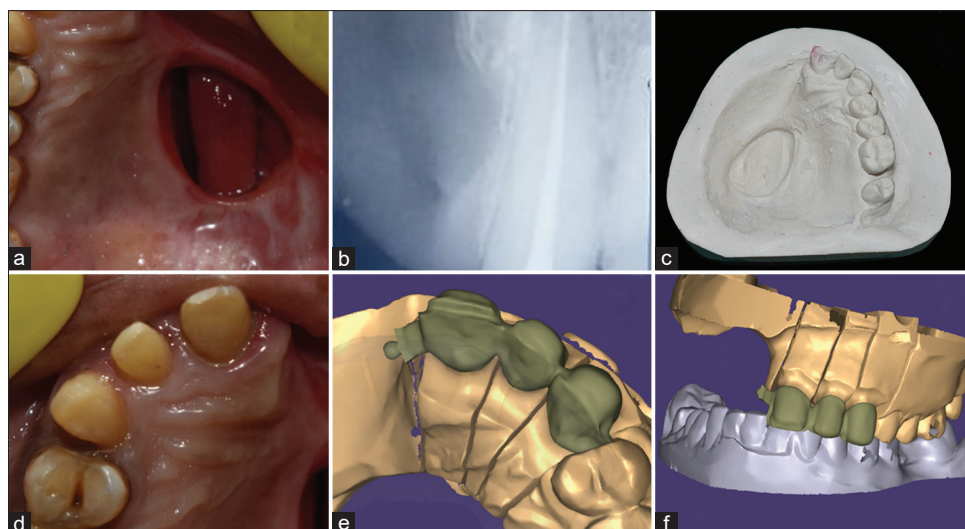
a) Intraoral view of the maxillary arch showing the healed margins of the defect, b) Radiograph revealing bony defect mesial to the left central incisor, c) Primary cast obtained from the impression, d) Tooth preparation with equigingival finish line on 21, 22, and 23, e) Designing of the crowns along with the precisagix attachment, f) Designing along with the mandibular scan to check for the proper occlusion
